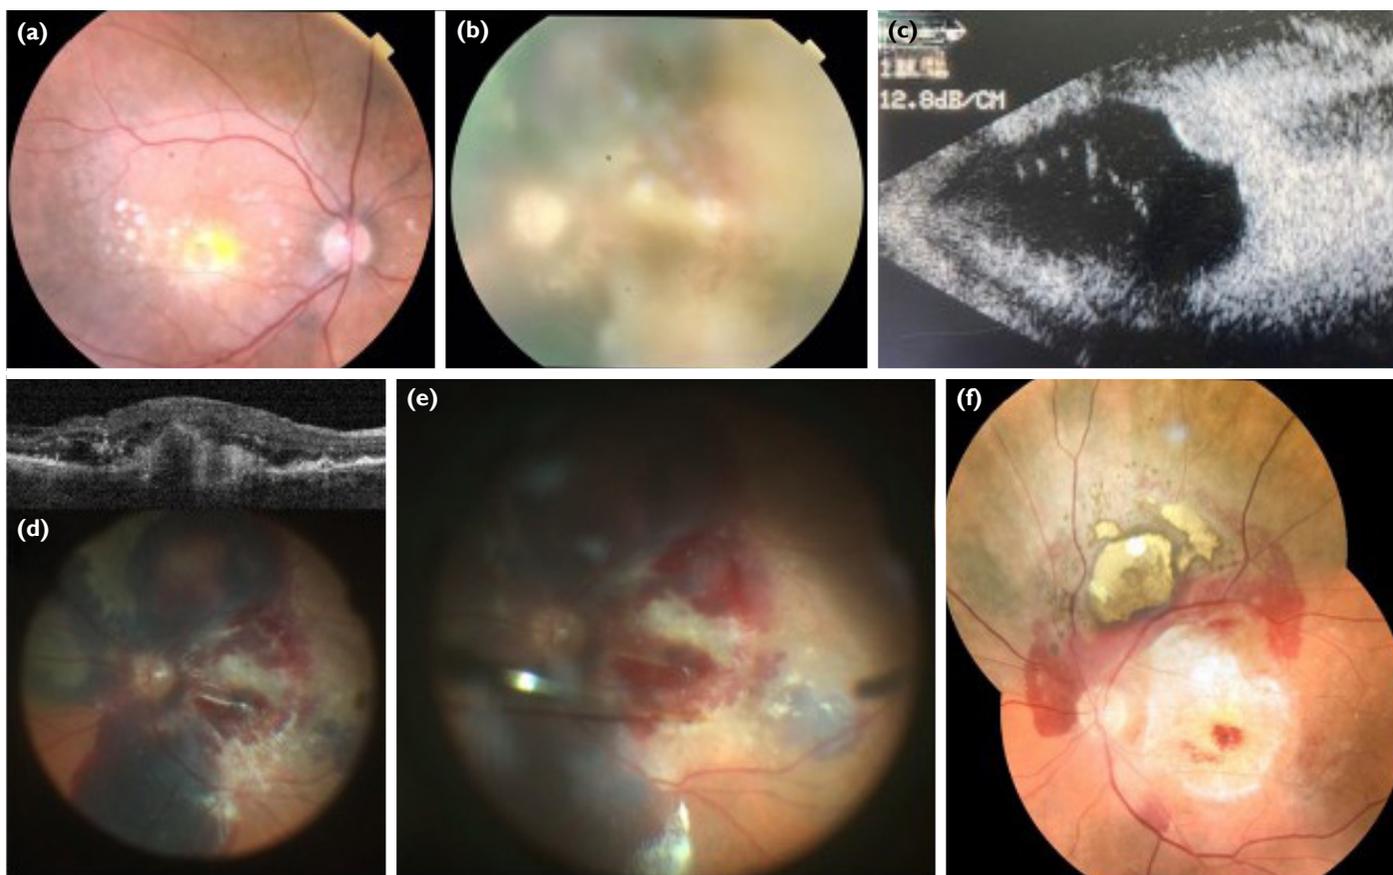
(Case-4) A 77-year-old male patient was admitted to our clinic with the decreased left vision for the past 7 days. (a) The patient's right fundus and OCT images show a fibrotic scar in his right eye. (b) There is a vitreous hemorrhage in the left fundus picture of the patient. A careful examination of the left fundus reveals subretinal hemorrhage under the retinal vessels. (c) A hemorrhage area is seen in the horizontal section of left eye ultrasonography. (d) Diffuse subretinal hemorrhage is seen after clearing the vitreous hemorrhage in the intraoperative image (e) subretinal tPA and bevacizumab injection. (f) Subretinal hemorrhages regressed in the fundus image in the 1st month postoperatively, but there is extensive atrophy in the fovea. The patient's left eye visual acuity was 2 mps.
